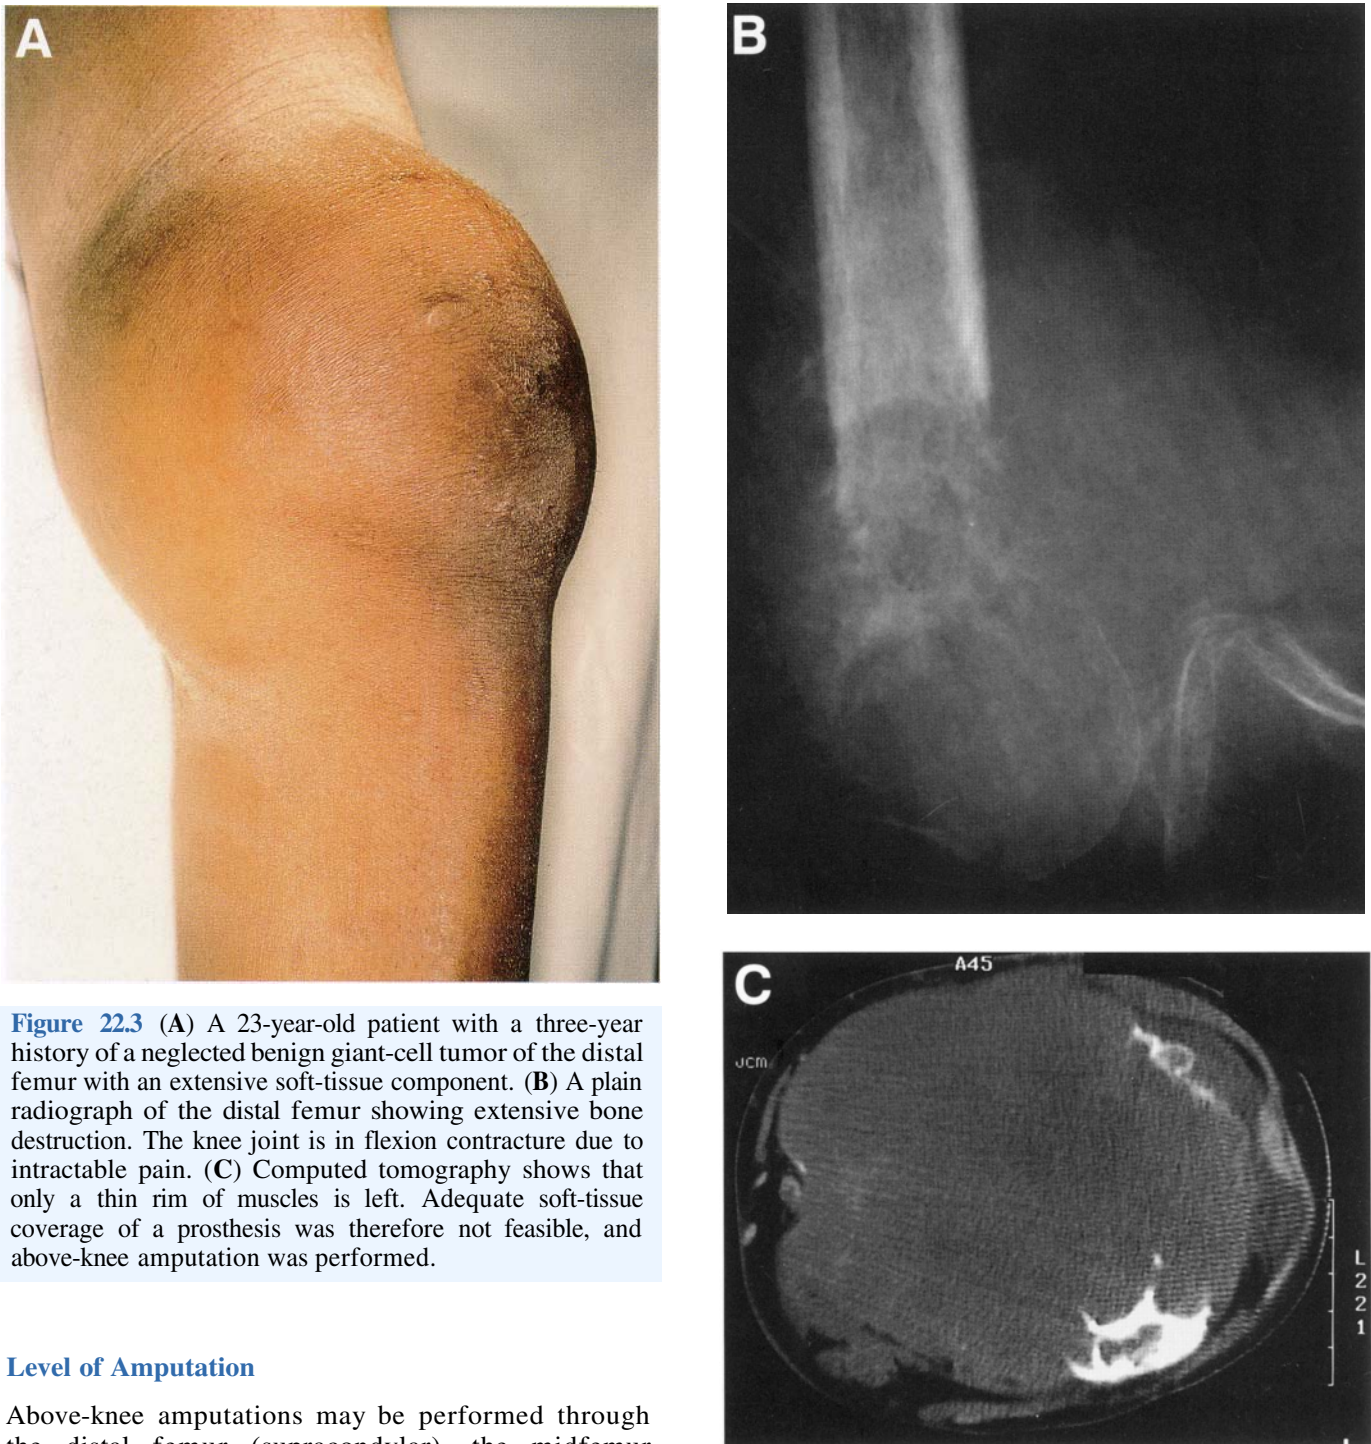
(A) A 23-year-old patient with a three-year history of a neglected benign giant-cell tumor of the distal femur with an extensive soft-tissue component. (B) A plain radiograph of the distal femur showing extensive bone destruction. The knee joint is in flexion contracture due to intractable pain. (C) Computed tomography shows that only a thin rim of muscles is left. Adequate soft-tissue coverage of a prosthesis was therefore not feasible, and above-knee amputation was performed.
